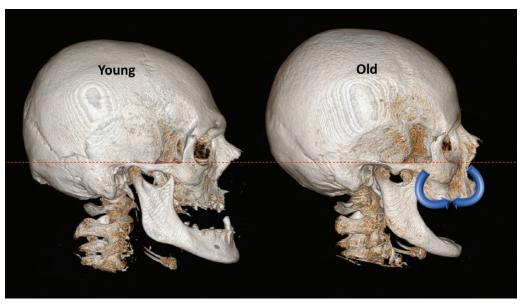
Comparison of the three-dimensional volume-rendered cranial computed tomographic scans of a young man versus an old man. The changes occurring in the midface of the old individual are summarized by the *blue arrows*. The *red dotted line* is used to compare the level of the upper margin of the zygomatic arch between individuals. Note the age-related loss in mandibular height.
